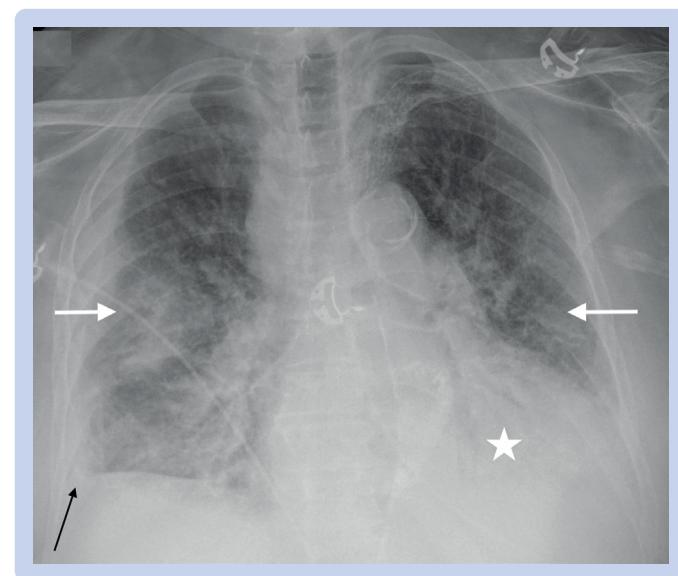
Chest radiograph with bilateral interstitial infiltrates (white arrows), bilateral pleural effusions (black arrow), and cardiomegaly (star)
